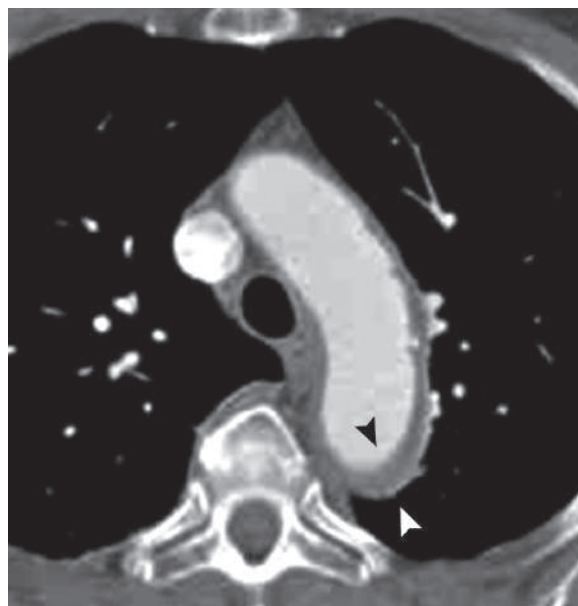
Axial cardiac CTA shows posterior aortic arch focal area of aortic wall thickening due to intramural hematoma (arrowheads)
